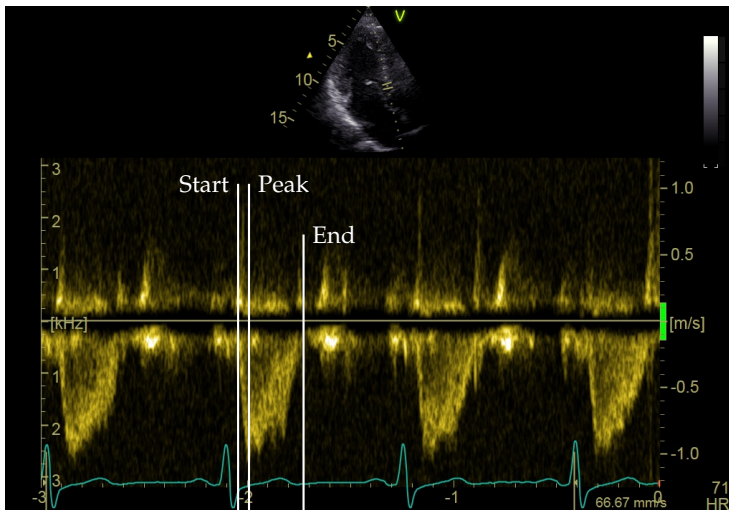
Pulsed Wave Doppler echocardiographic image from a participant of the study (N24). Start, peak and end of the blood flow out of the ventricle is annotated with the white vertical lines.
